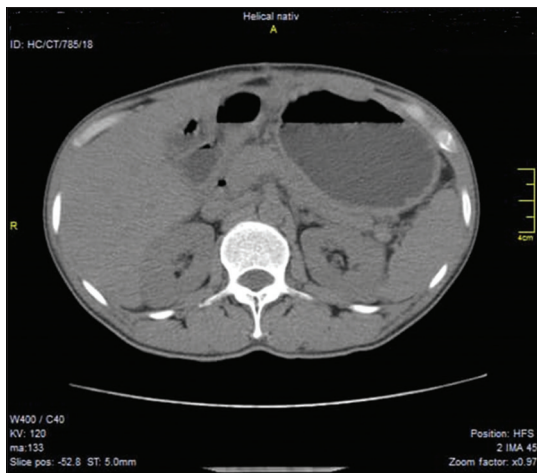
Posttreatment axial unenhanced CT of the abdomen demonstrating resolved pancreatic head mass
